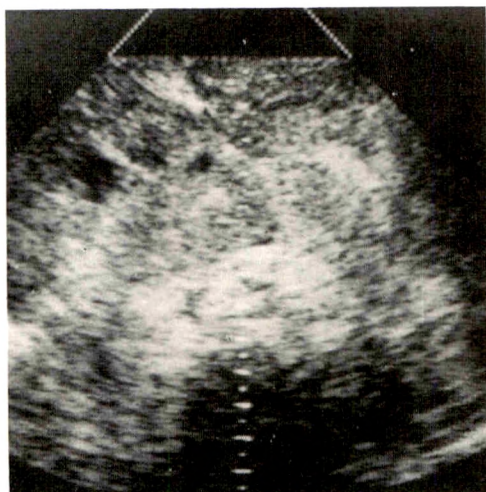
Hemorrhagic pancreatitis caused by valproic acid in a 4.5-year-old boy. Abdominal sonogram shows diffuse pancreatic enlargement with overall increased echogenicity and focal areas of brighter echogenicity. Other images showed generalized bowel distension and ascitic fluid. Repeat sonogram on hospital day 19 (not shown) showed a large pseudocyst. (Reprinted with permission from Rosenberg and Ortega [14].)
